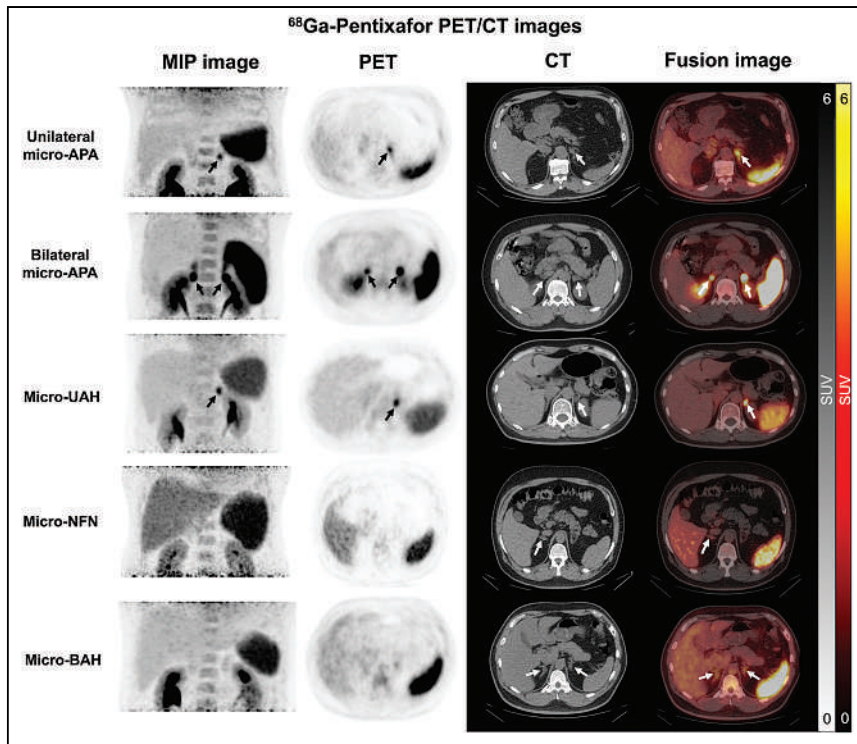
Performance of ^{68}Ga -pentixafor PET/CT in PA patients with different adrenal micronodules. MIP = maximum-intensity projection; NFN = nonfunctioning nodule.
